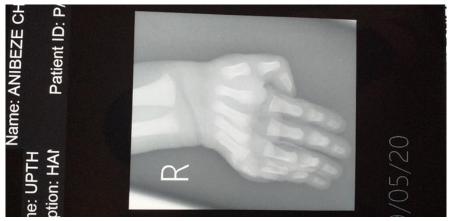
Showing xray of right hand with fully developed bone on six digit
